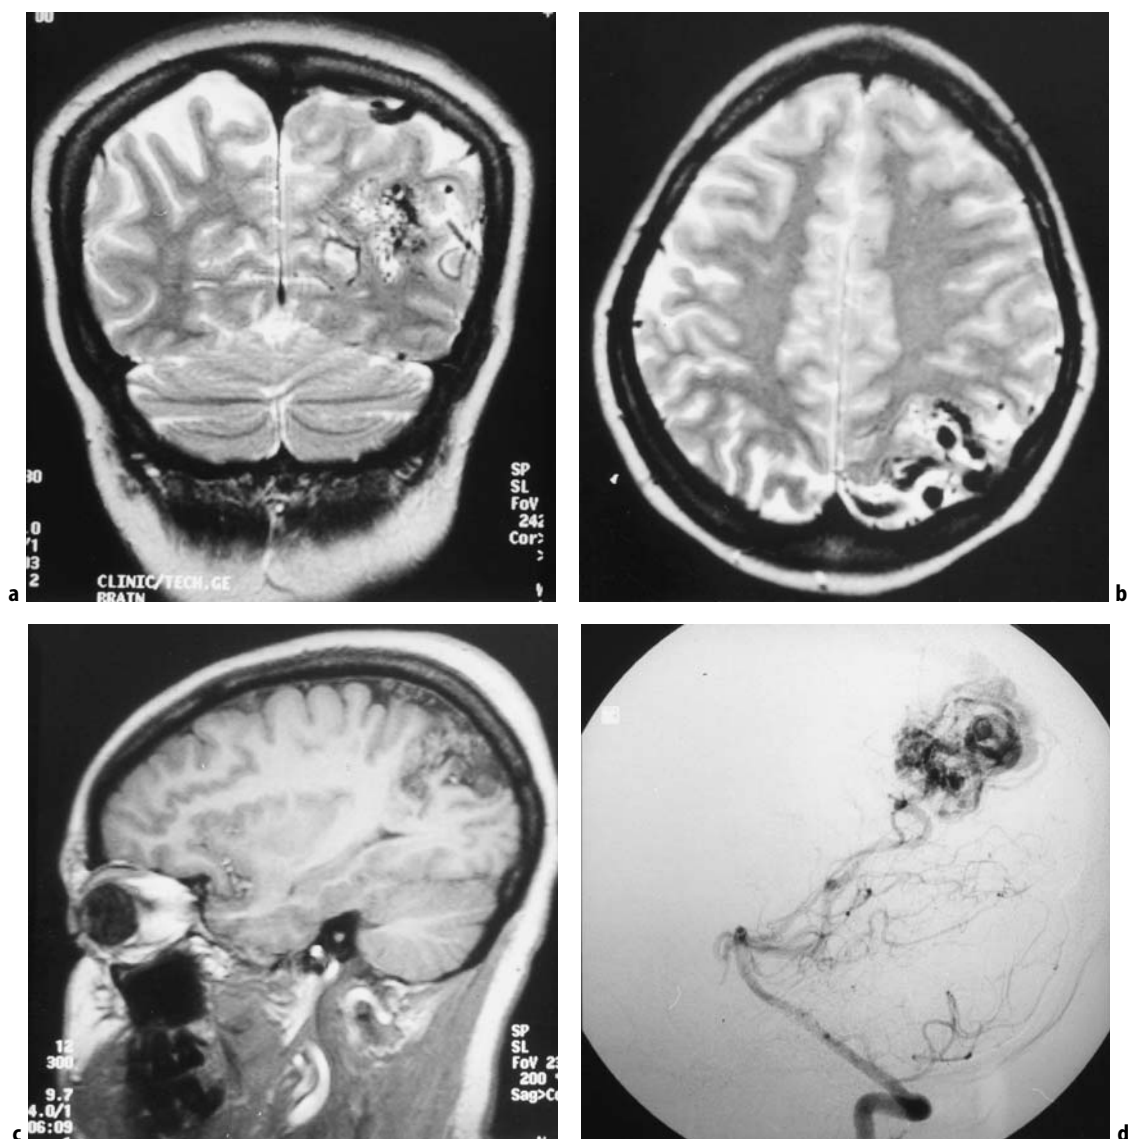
Case 1: A 37-year-old woman presented with a generalized seizure. a A T2-weighted coronal MRI was obtained through the posterior cerebral cortex and cerebellar hemispheres. A cluster of flow voids characteristic of an AVM nidus and its draining veins was located in the left parietal-occipital lobe. b An axial T2-weighted MRI through the cerebral convexity demonstrated a cluster of large, dilated draining veins in the left posterior parietal lobe. c A left parasagittal T1-weighted MRI with contrast administration showed a classic wedge-shaped nidus with the apex pointing towards the lateral ventricle. There was patchy contrast enhancement within the nidus. The nidus was approximately 3–4 cm in diameter. Catheter angiography was performed for treatment planning. d A lateral, mid-arterial phase right vertebral artery cerebral angiogram revealed the dysplastic nidal vessels being fed by branches of the left parieto-occipital artery. Early venous opacification was noted superficial to the AVM.
